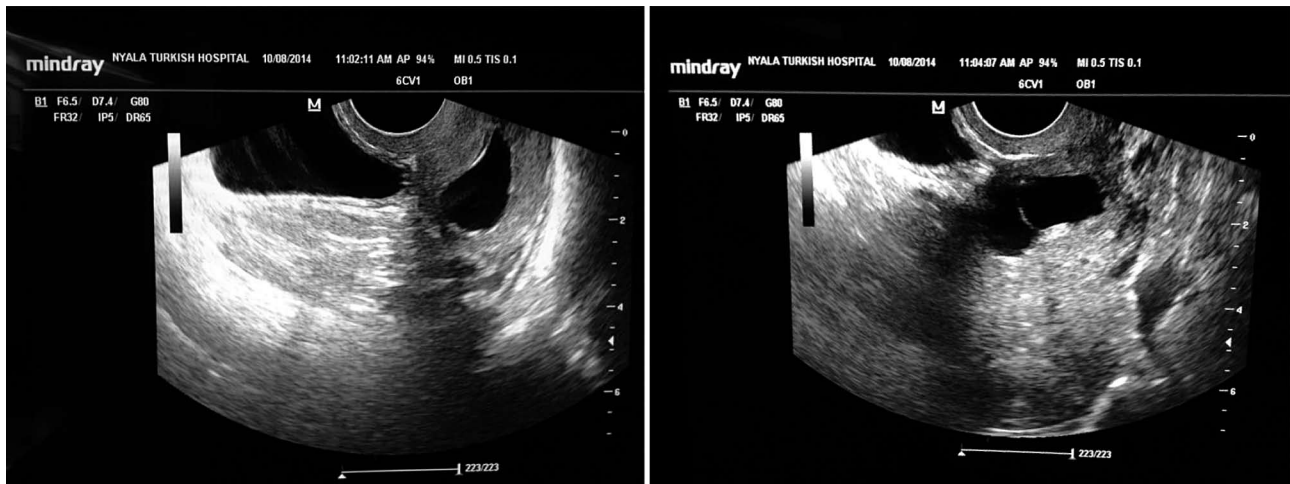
Ultrasound images of a gestational sac on the front wall of isthmus where myometrium measures under three-mm thick.
